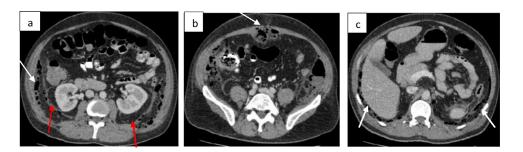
Axial cuts of preoperative abdominal CT with I.V. and oral contrast.
